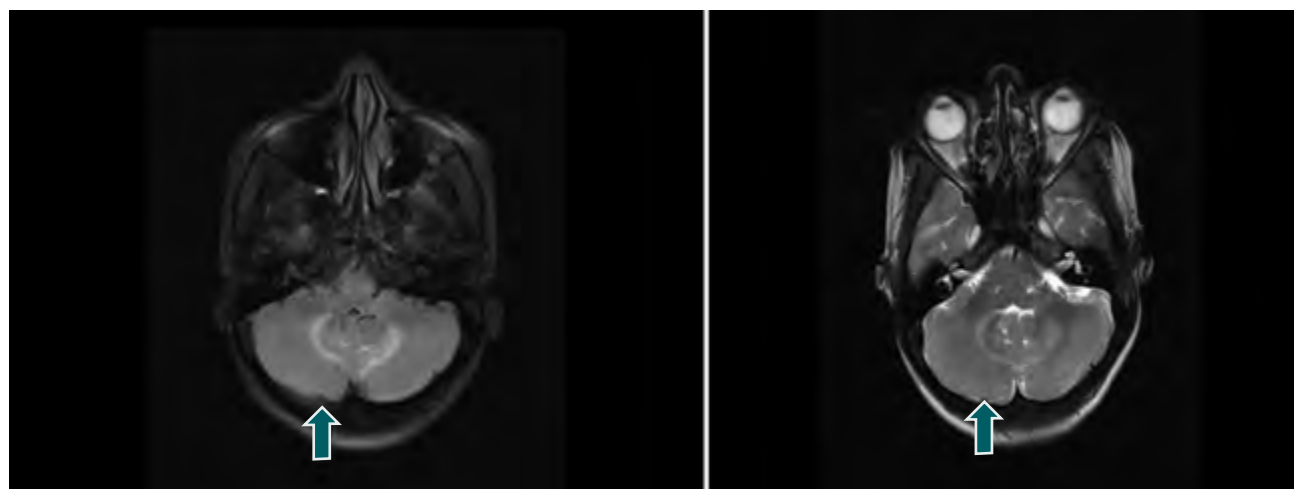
Contrast-enhanced MRI brain showing bilateral cerebellar hyperintensities (arrows) on T2 FLAIR (left) and T2 images (right) suggestive of bilateral cerebellitis.
